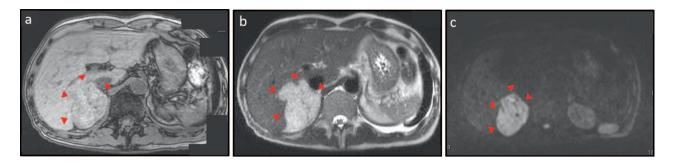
Abdominal MRI shows a signal-hyperintense mass on T1- (a), T2- (b), and diffusion-weighted (c) images. Tumor has infiltrated the posterior segment of the right hepatic lobe and is close to the IVC (red arrows).
